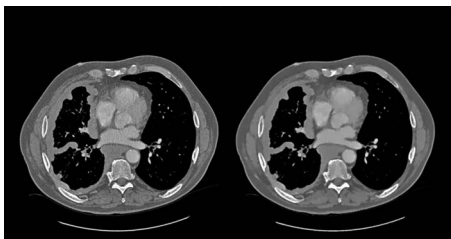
Left: Axial CT section with MPM in the right hemithorax. Right: Nonlinear diffusion smoothed CT section.
